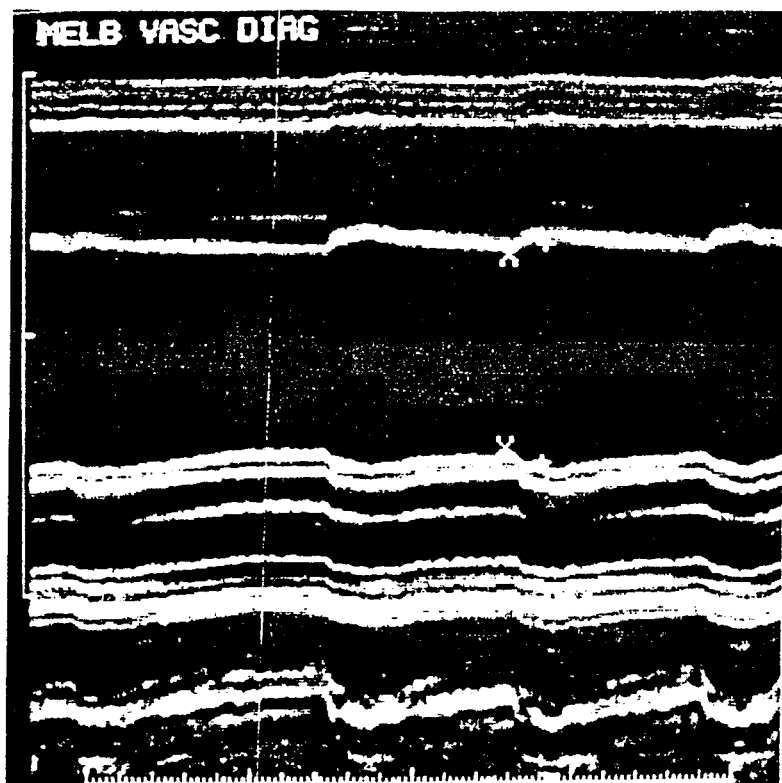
M-mode ultrasound imaging of the arterial wall showing the degree of wall movement through the pulse which allows calculation of the elastic modulus
